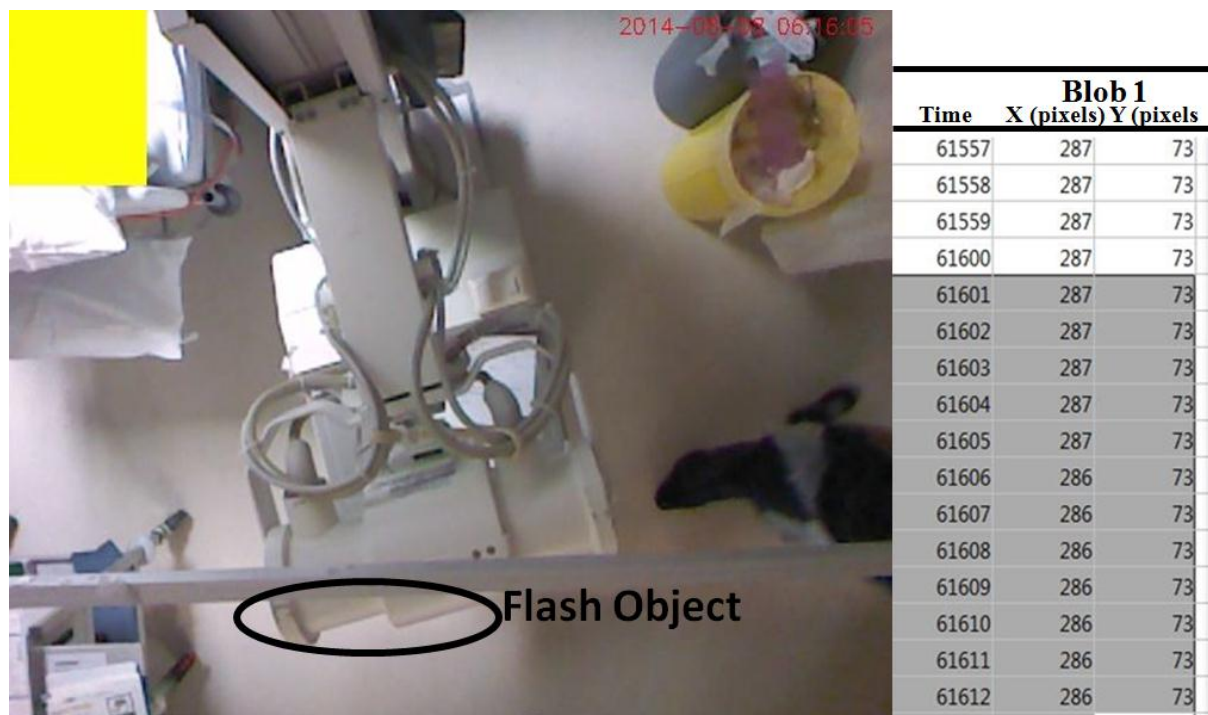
An X-ray machine appeared in K2 area. Circled part reaches the maximum detection depth range, thus blob x position is switching between 286 and 287, as shown at the right side. Circle part of X-ray machine is traded as flashing object.
